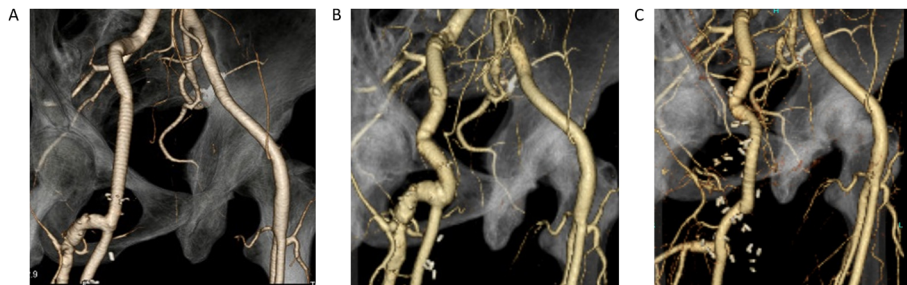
Postoperative computed tomography images. (A) Reconstructed iliofemoral artery after the first surgery. (B) Progression of right deep femoral artery aneurysm after 6 years. (C) Reconstructed deep femoral artery after the second operation.
